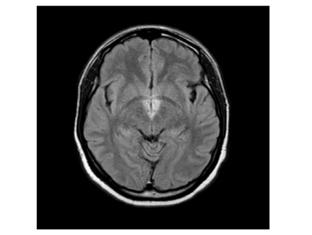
Hypothalamic NMO Lesion. T2-weighted FLAIR axial view showing bilateral hyperintense signals of the hypothalami.
